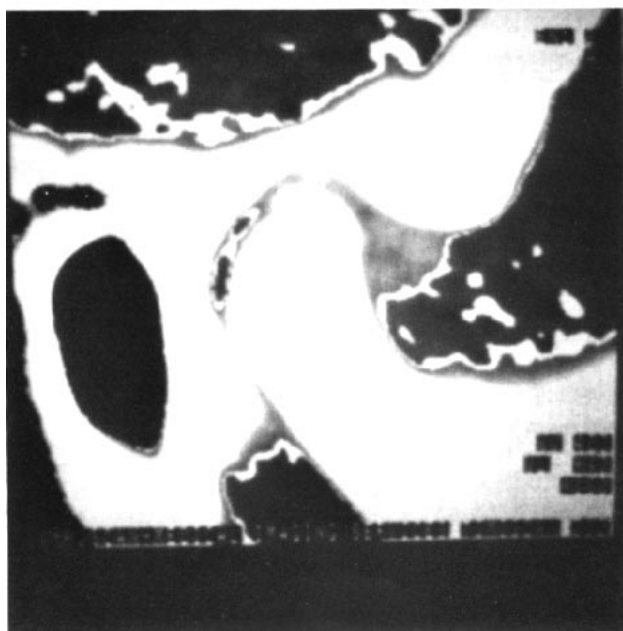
The same joint seen in Fig. 8, visualized from the same CT exposure with soft tissue window technique
